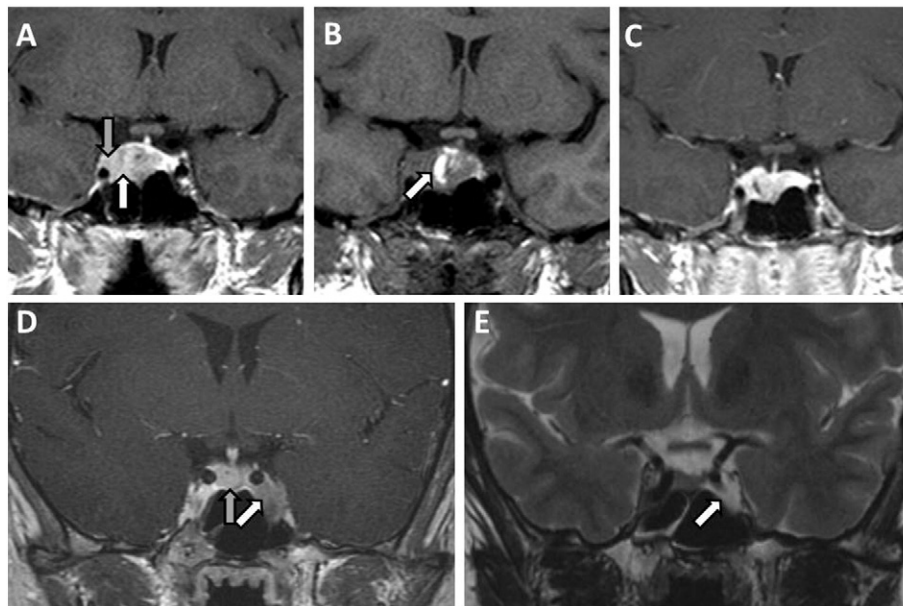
Magnetic resonance images. Figure parts A–C correspond to Case 1; parts D–E correspond to Case 2. A, T1 coronal image with gadolinium shows a pituitary macroadenoma with right cavernous sinus invasion (white arrow indicates pituitary tumor, gray arrow indicates right cavernous sinus invasion). B, T1 coronal image without gadolinium during pregnancy shows apoplexy (white arrow indicates intratumoral hemorrhage). C, T1 coronal image with gadolinium shows reduced tumor size after dopamine agonist therapy 6 months after her first pregnancy with persistent right cavernous sinus invasion. D, T1 coronal image with gadolinium shows an asymmetric soft-tissue area in the left cavernous sinus (white arrow), which corresponded to a 1.1-cm macroprolactinoma (gray arrow indicates normal pituitary tissue). E, fast spin-echo image 4 years after radiosurgery shows tumor involution in the left cavernous sinus (white arrow).
